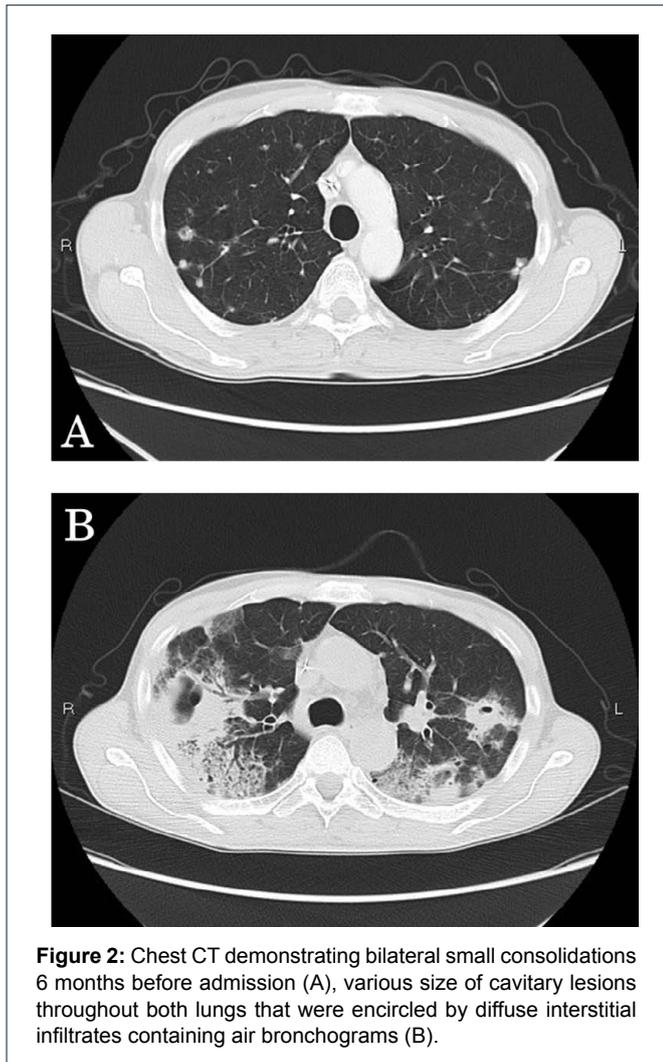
Chest CT demonstrating bilateral small consolidations 6 months before admission (A), various size of cavitary lesions throughout both lungs that were encircled by diffuse interstitial infiltrates containing air bronchograms (B).
